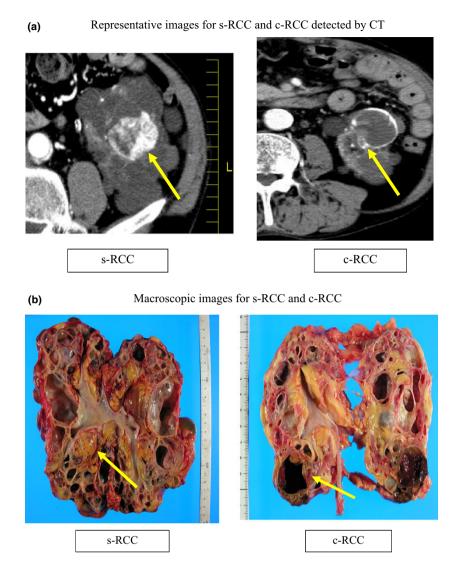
(a) Shows representative images of solid-type RCC (s-RCC) and cystic-type RCC (c-RCC) detected via CT. (b) shows macroscopic images of s-RCC and c-RCC.
